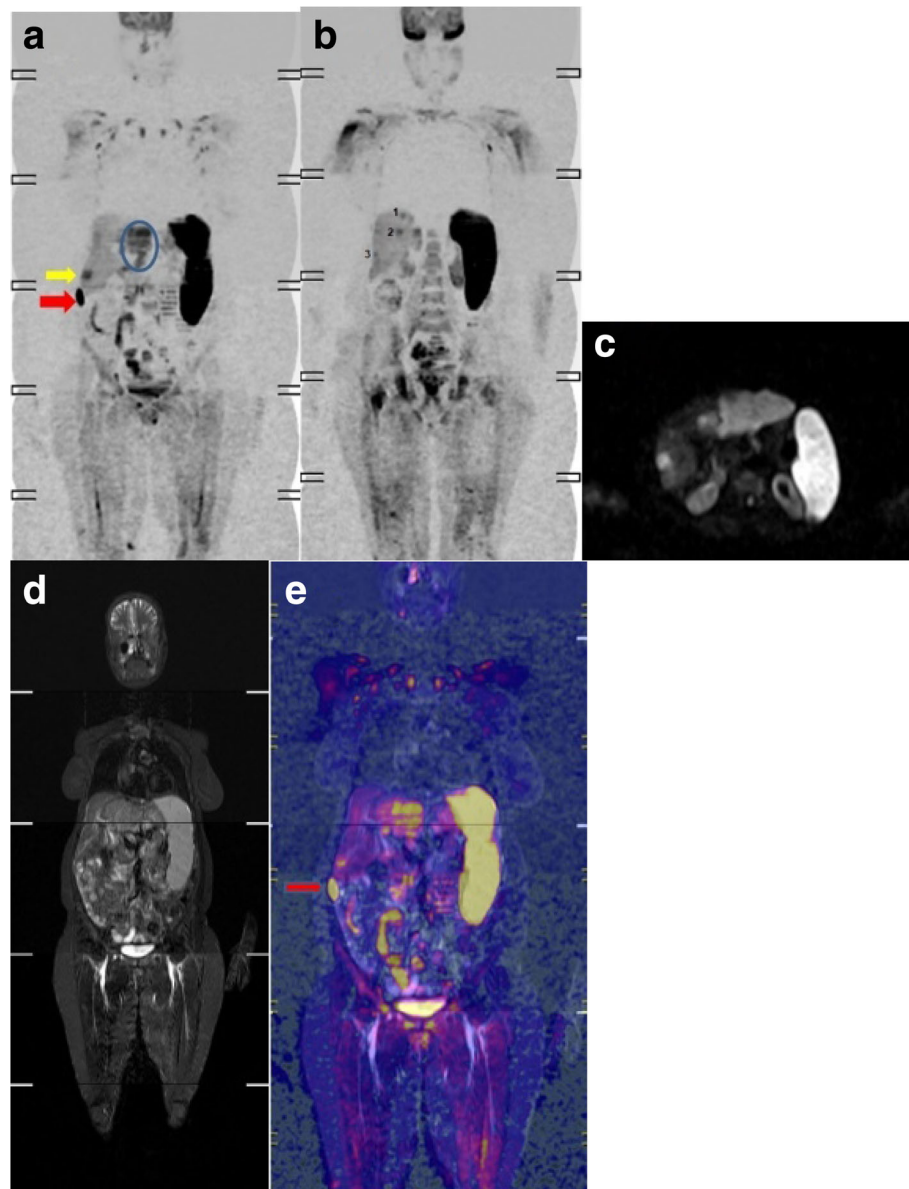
A 55-year-old female patient with metastatic hepatocellular carcinoma (HCC). a Coronal WB DWI. Left lobe HCC (circle) and a metastatic hepatic focal lesion (yellow arrow). Note splenomegaly. b Coronal WB DWI. Multiple metastatic hepatic focal lesions (three lesions). c Axial DWI. Left lobe HCC and hepatic focal lesions. d Coronal STIR. Liver lesions are not clearly shown as in DWI. e Fusion images of both DWI and STIR. Hepatic flexure of the colon can be misinterpreted as a hepatic focal lesion (red arrow)
